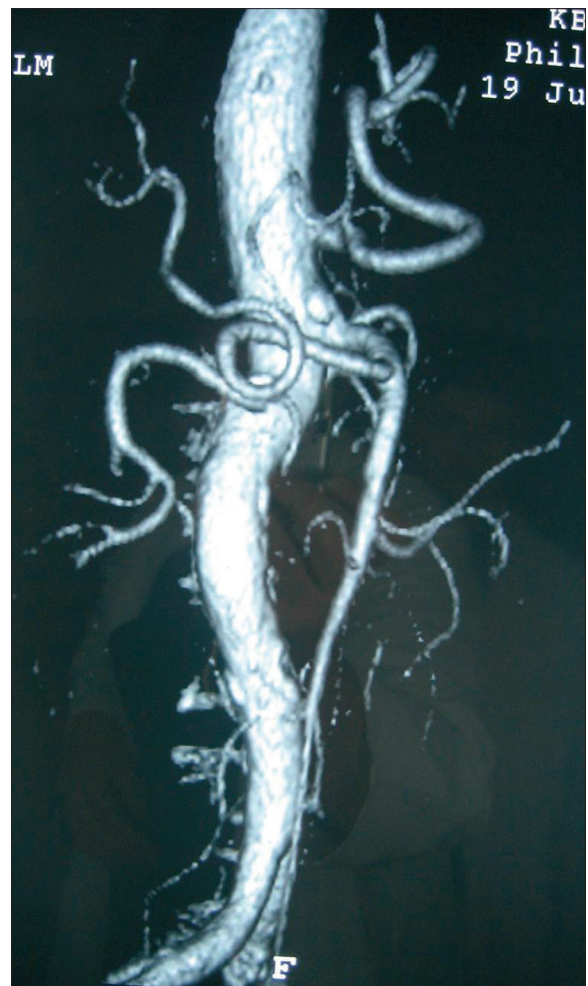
CT angiography of the abdominal aorta and its branches – arterial ring of the proper hepatic artery is clearly visible.
